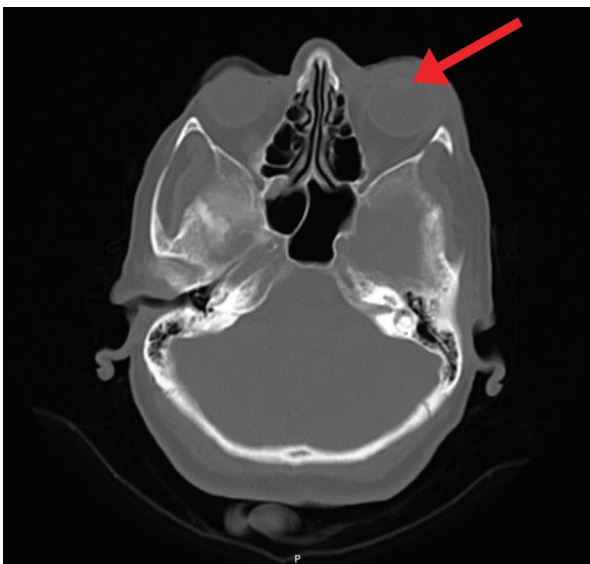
Edematous image in the left eye and soft tissue in the patient's computed tomography (arrow)
